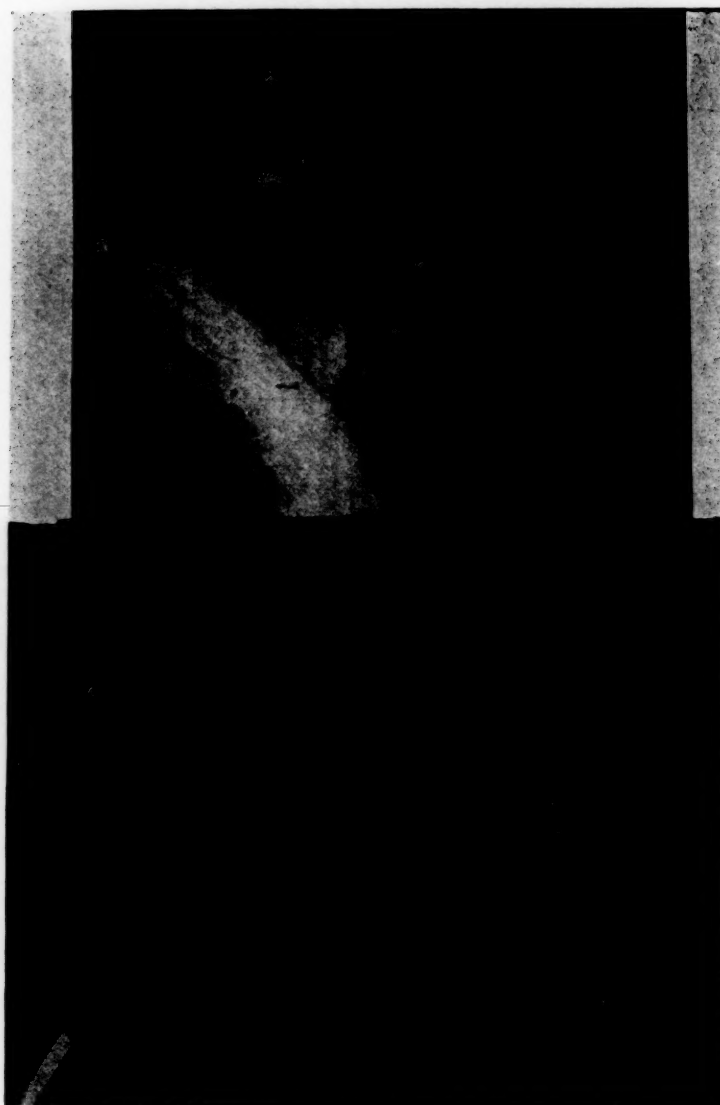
X-ray films of hands and affected shoulder of patient in Figure 1 showing decalcification of wrist and hand and some osteoporosis at humeral head.
